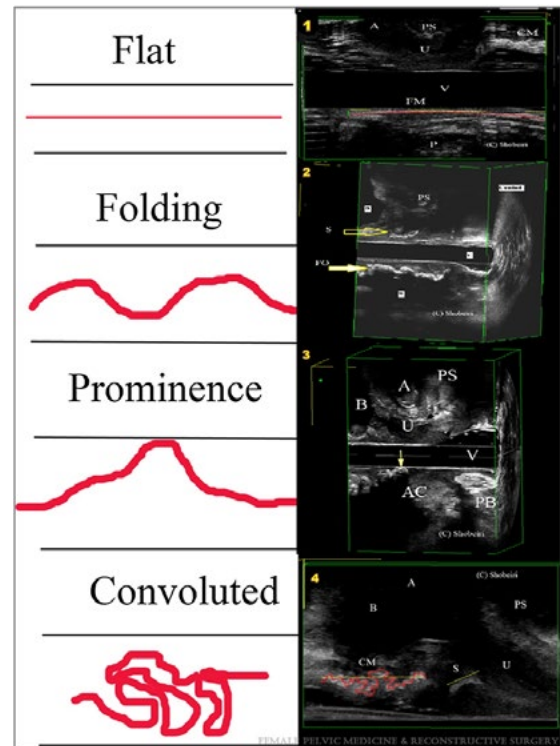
Three-dimensional ultrasound images depicting vaginal mesh location and patterns based on their US manifestation: (1) flat posterior mesh in the same patient as convoluted anterior mesh, (2) left lateral view of folded mesh and anterior sling, (3) mesh prominence posterior mesh, and (4) convoluted anterior vagina mesh and sling. Arrows indicate mesh location. A, anterior; AC, anal canal; B, bladder; CM, convoluted mesh; FM, flat mesh; FO, folded mesh; P, posterior; PS, pubic symphysis; PB, pubic bone; R, rectum; S, sling; U, urethra; V, vagina.
